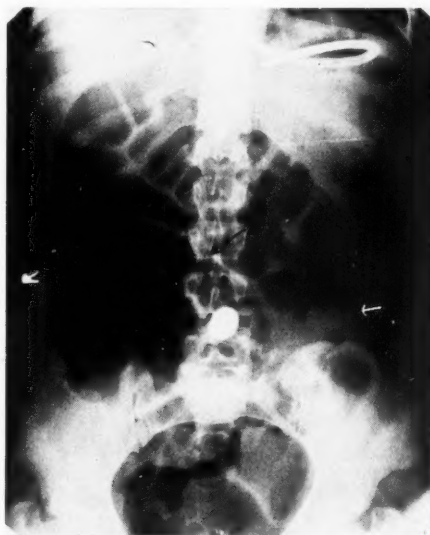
Roentgenogram of abdomen, supine position, in a case of acute obstruction of the colon from carcinoma of the splenic flexure. Note column of gas stopping abruptly at soft-tissue density (arrow) which indicates location of tumor. Note gas in loops of small bowel (central arrow) due to pressure of tumor on small intestine rather than to regurgitation through the ileocecal valve.
